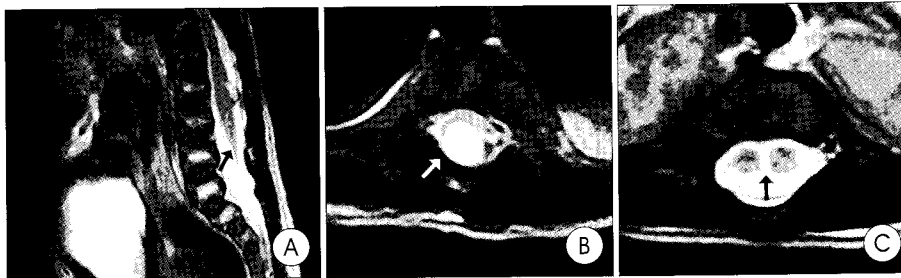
Spinal magnetic resonance images show multiple spinal anomalies including a tethered cord (A, arrow), hydromyelia in thoracic and lumbar spinal cord (B, arrow) and diastematomyelia from T11/12 to L4 level (C, arrow).
